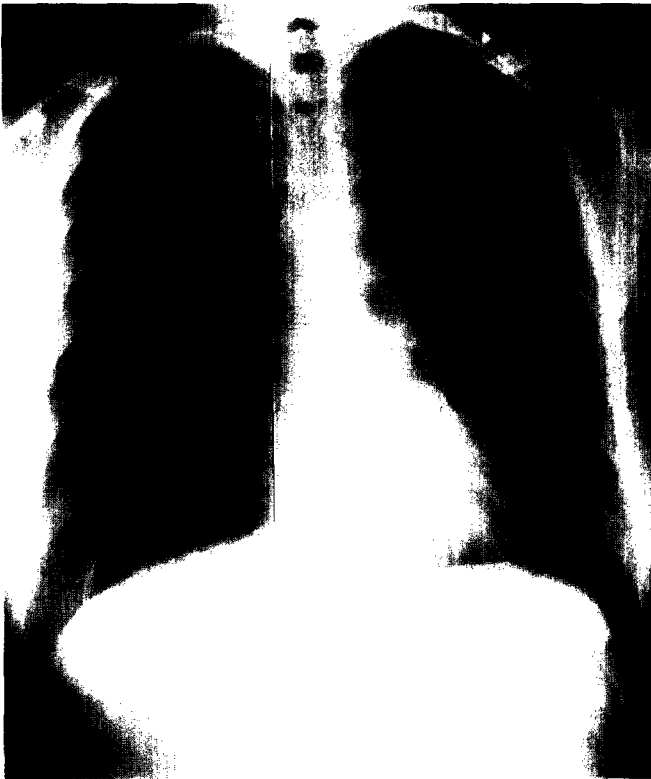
Chest roentgenogram showing the typical air crescent sign in a 31-year-old with cavitating IPA in the left upper lobe
